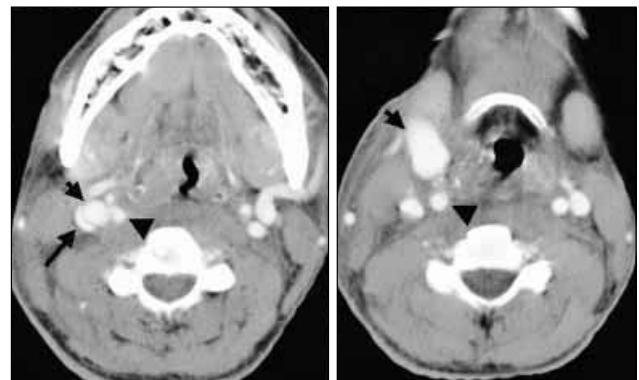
Neck computed tomographic scans showing a vascular mass (short arrow) protruding the anterior neck, which is connected with fistulous tract from the internal carotid artery (arrowhead). The internal jugular vein (long arrow) is compressed by the vascular mass.
